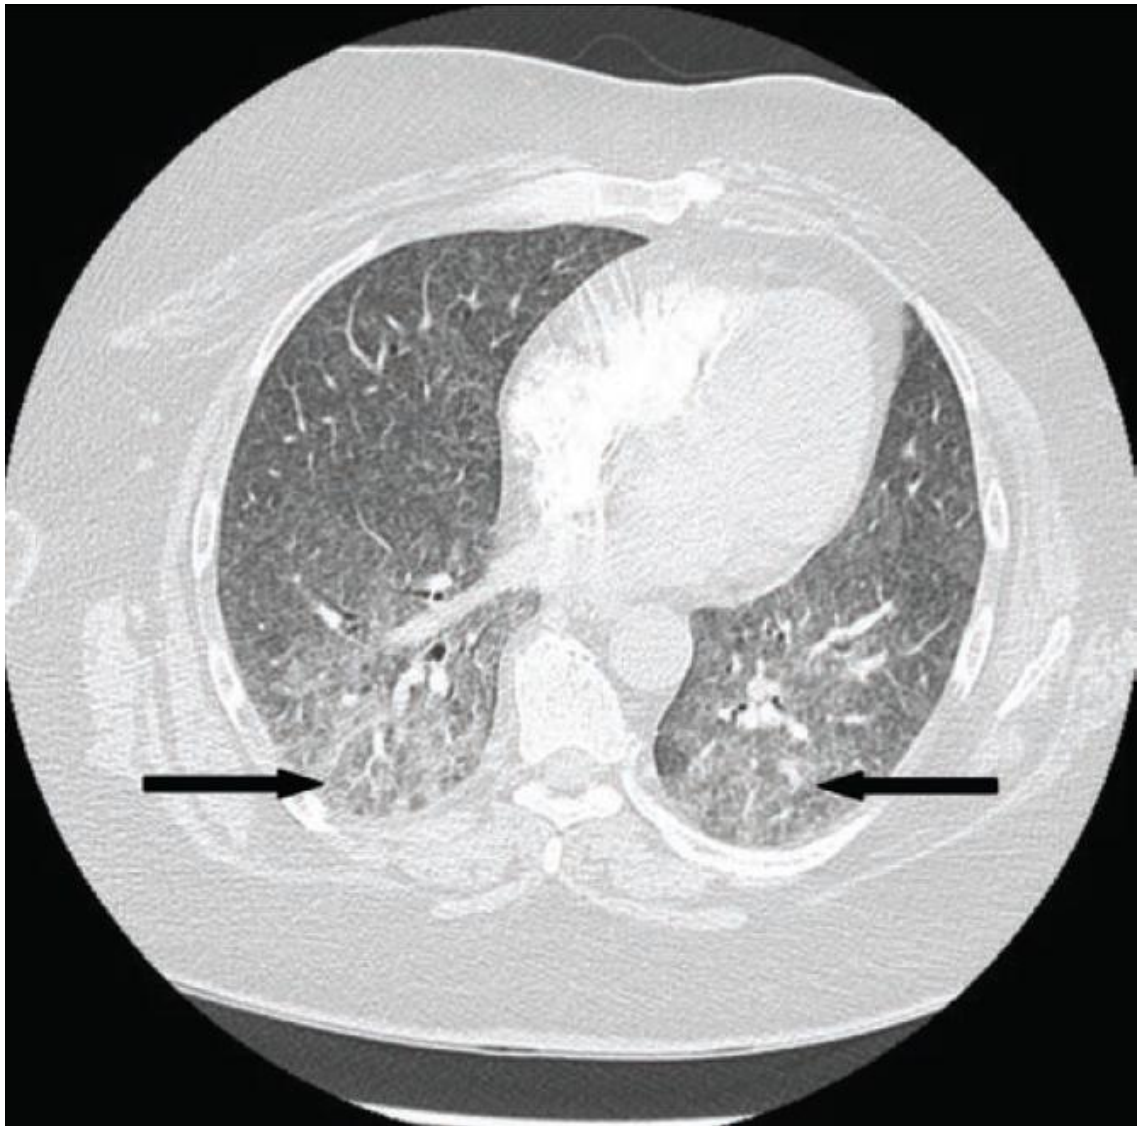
High-resolution CT scan of MTX-P. Note the ground-glass shadowing present bilaterally (arrows)^e.
